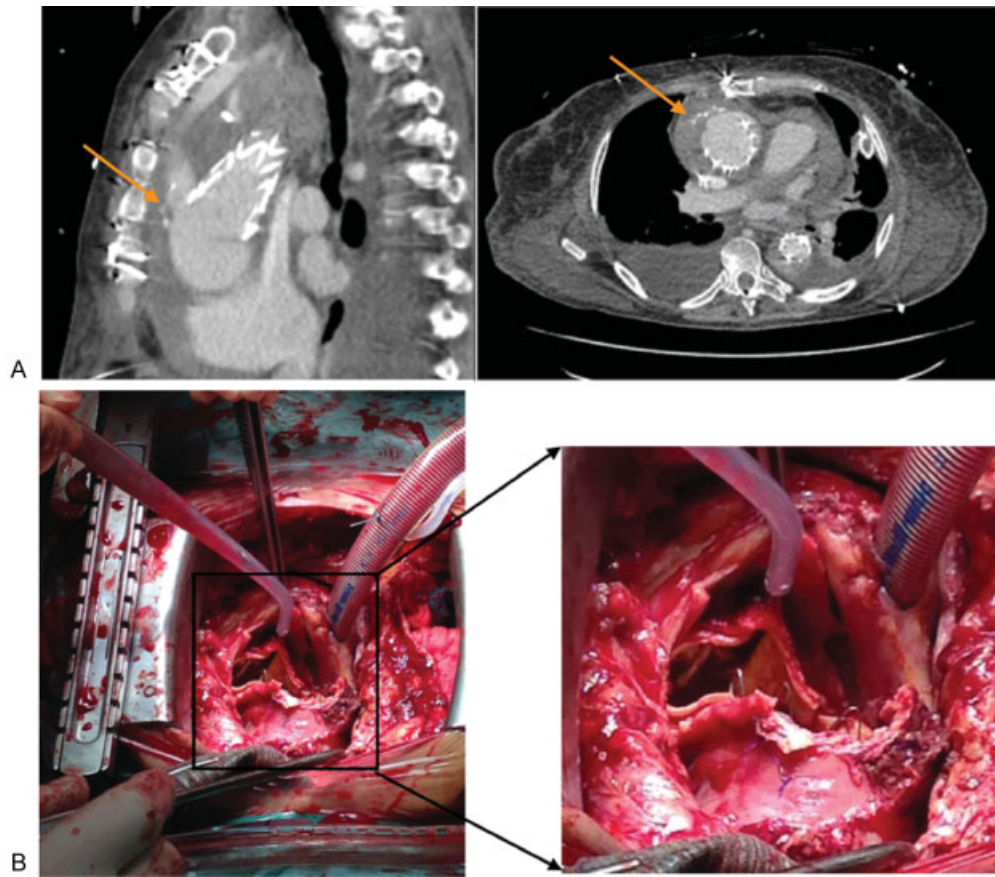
Computed tomography (CT) scan confirming active bleeding (A). Intraoperative findings of ascending aorta tear and active bleeding (B).
